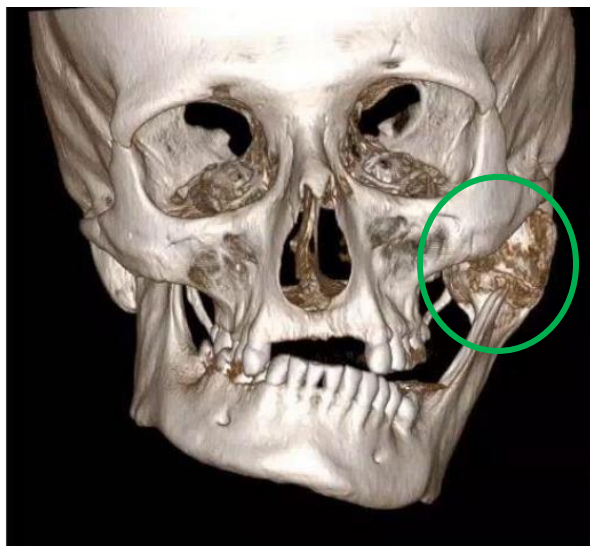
Computed tomography, 3D reconstruction, anterior view. Proliferative lesion of the left TMJ inside the green circle (RadiAnt DICOM Viewer 2025.2).
